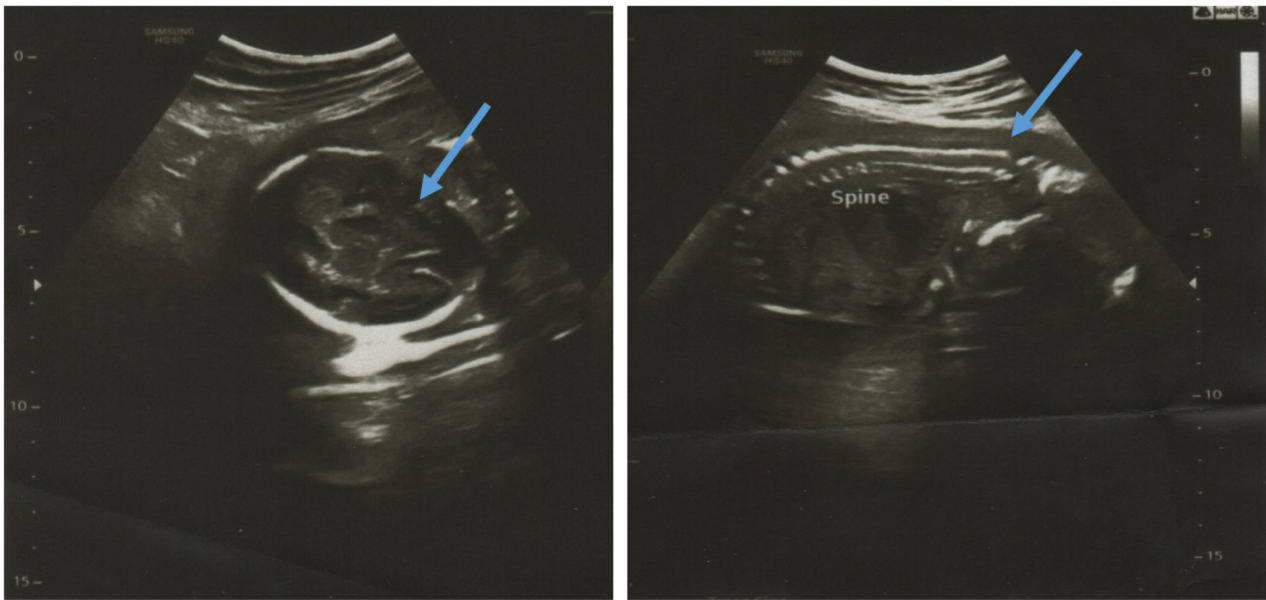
Trans-abdominal ultrasound revealing a normal fetal spine and reduced amniotic fluid at 20 weeks of pregnancy. The blue arrow indicates to the area of decreased amniotic fluid.
